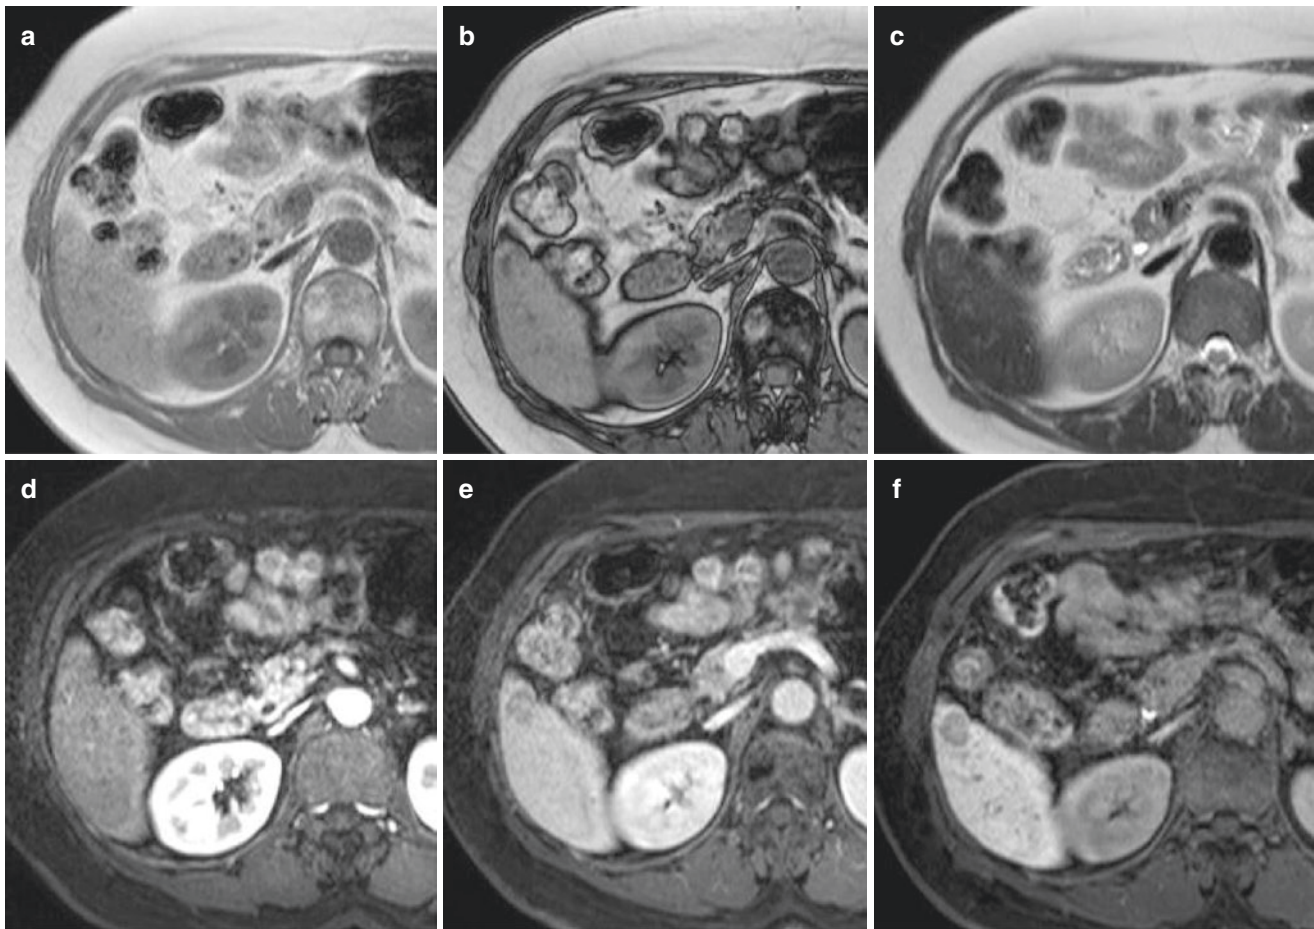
MRI images of early HCC. In-phase T1-weighted image (a), out-of-phase T1-weighted image (b), T2-weighted image (c), arterial-phase image of Gd-EOB-DTPA contrast-enhanced MRI (d), portal phase image of Gd-EOB-DTPA contrast-enhanced MRI (e), and hepatobiliary phase image of Gd-EOB-DTPA contrast-enhanced MRI for
